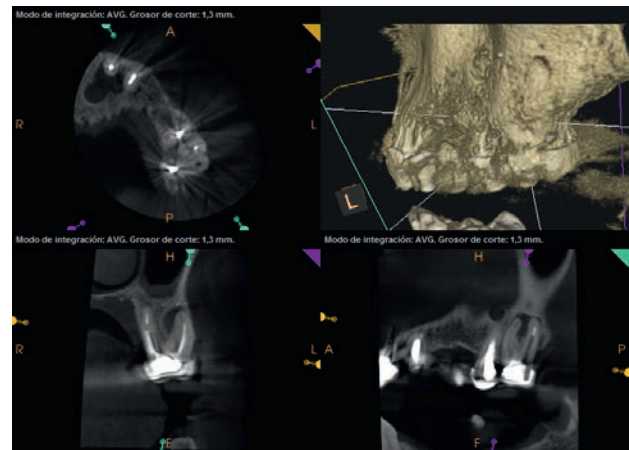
Upper left first molar MB preoperative CBCT image where omitted MB2 root canal can be seen.
